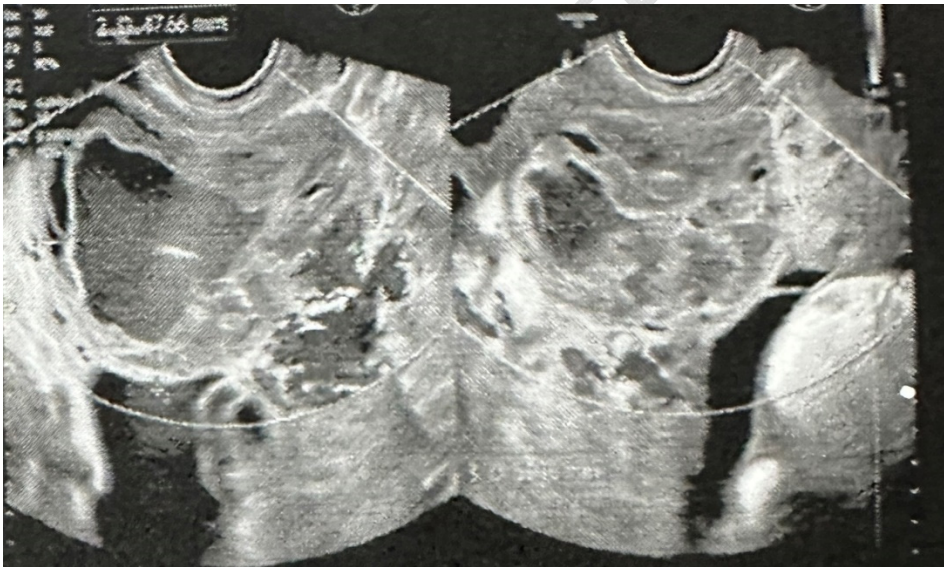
The ultrasound image reveals a cystic area within the uterine cavity measuring 3.7 mm with an echogenic content and a solid mass measuring 8 x 3 mm. There is no evidence of increased vascularity
